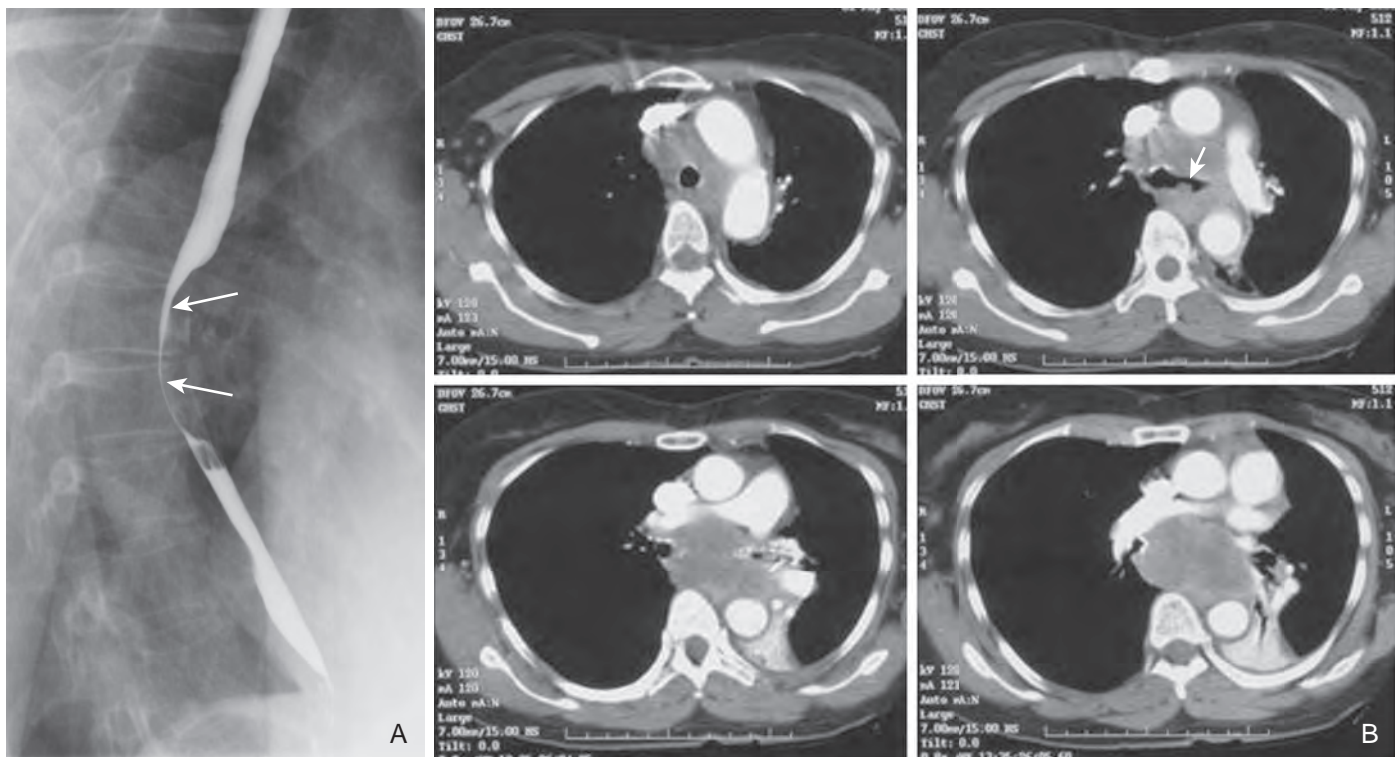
Esophageal compression by mediastinal lymphadenopathy from carcinoma of the lung. A. Barium study shows a large extrinsic indentation (arrows) on the anterolateral wall of the midesophagus just below the carina. B. CT scan shows bulky mediastinal and subcarinal adenopathy as the cause of this finding. An endobronchial lesion (arrow) is also seen in the left main bronchus near the carina. This patient was found to have a small cell carcinoma of the lung. (Courtesy Vincent Low, MD, Perth, Australia.)
